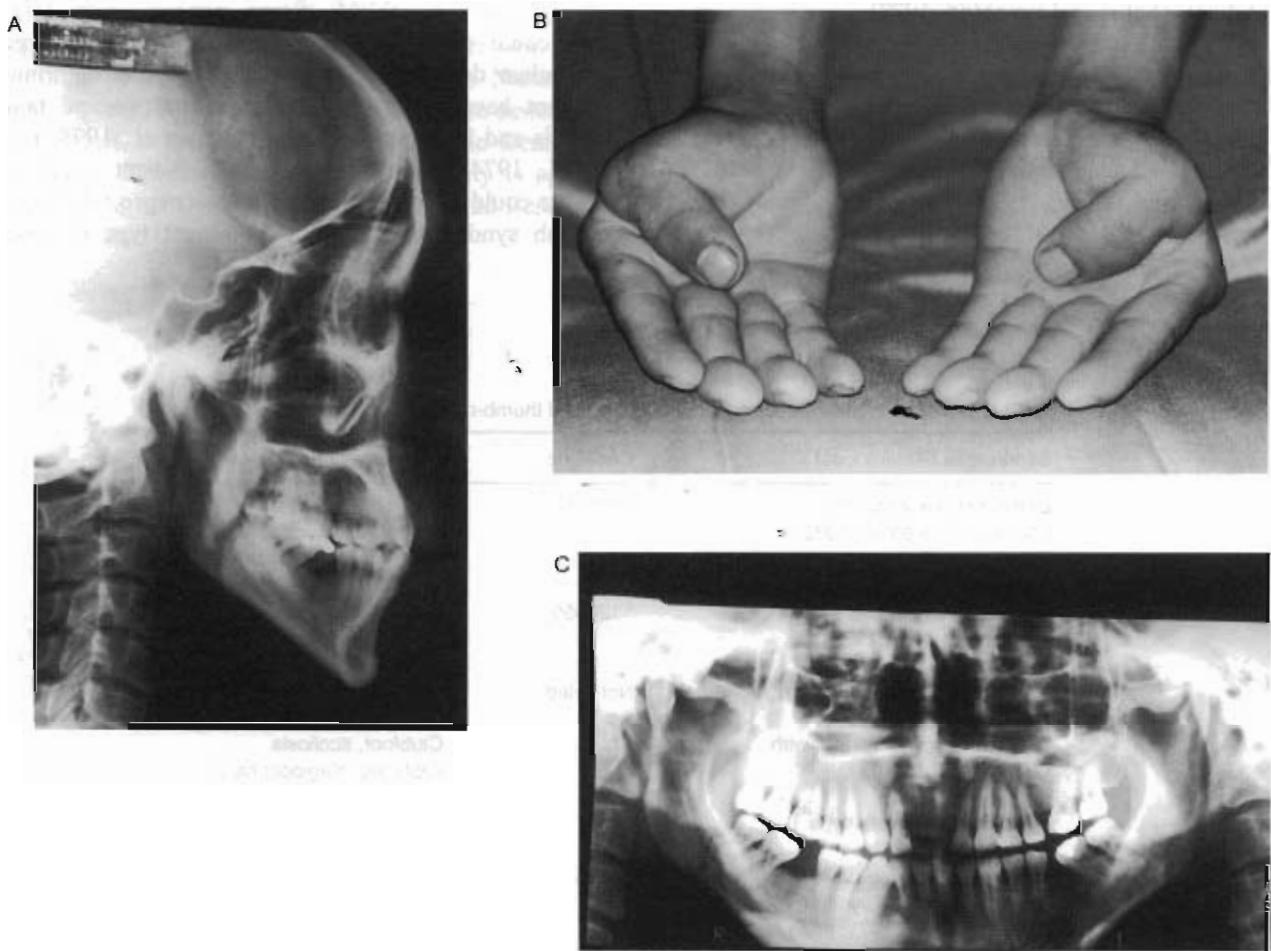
Patient 2. A) Lateral skull X-ray shows large posterior clinoid process and large opening of the sella turcica. B) Patient 2's hands. Thumbs are clasped at MCP joints with ulnar deviation of fingers. C) Panoramic radiograph reveals large left zygomatic arch and flat left condylar head.
